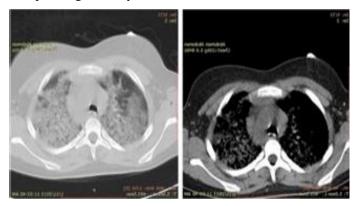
CT scan of the thorax showed diffuse alveolar interstitial infiltration. CT guided Trans bronchial lung biopsy was sent to the laboratory.
